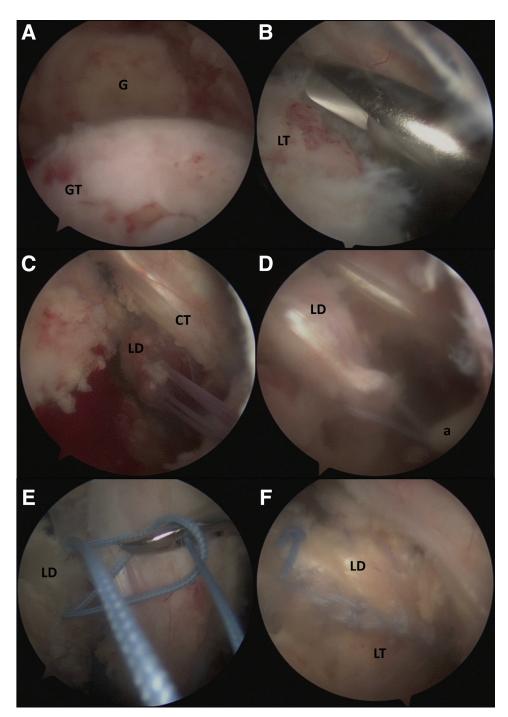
Latissimus dorsi (LD) attachment on lesser tuberosity (LT) (right shoulder with patient in beach-chair position; lateral view). (A) Scope in lateral portal for LD fixation. (B) Preparation of LT with burr. (C) The LD tendon is retrieved to the LT. (D) LD fixation with 2 knotless anchors (a) (lateral row) on superior and inferior sutures. (E) Lasso loop on medial anchor to create third point of fixation on LT. (F) LD transfer fixation on LT for irreparable subscapularis tear. (CT, conjoint tendon; G, glenoid; GT, greater tuberosity.)
